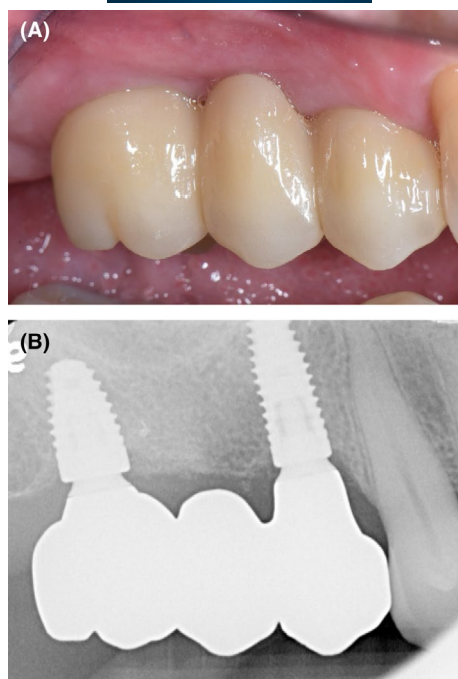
(A) A milled zirconia 3-unit prosthesis has been connected to the implants in the maxillary right first premolar and first molar sites. The prosthesis is overcontoured and uncleanable by the patient. (B) The periapical radiograph of the prosthesis.
